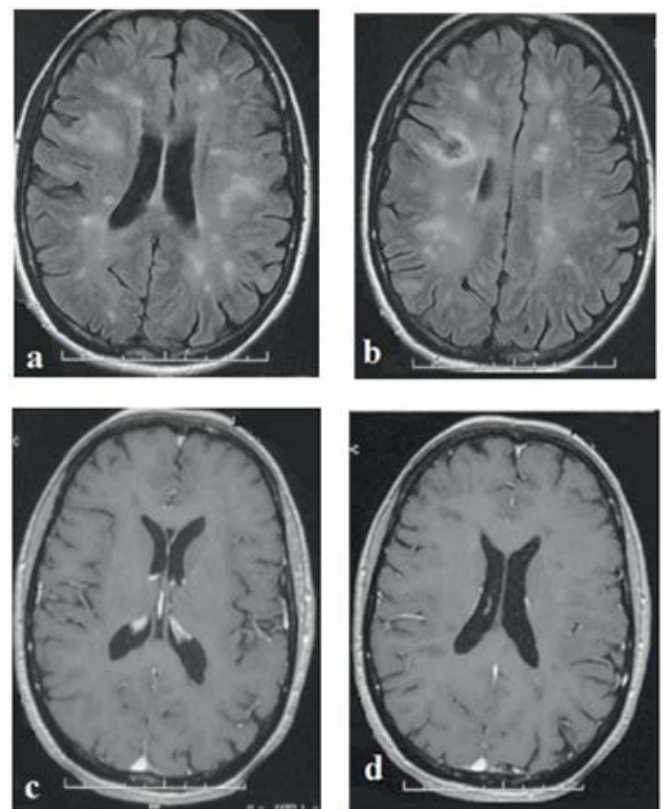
Brain MRI (09/2011): Axial (FLAIR) (a,b) and post contrast T1w (c,d) images showing a regression of hyperintense lesions of the white matter with absence of enhancement.
